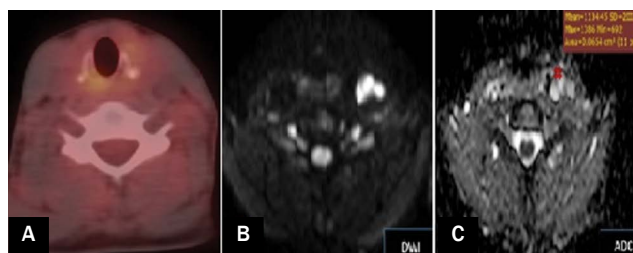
31-year-old woman presented with PTC, underwent total thyroidectomy. Follow up assessment (3 months post-thyroidectomy): revealed rising TG level reached 7.1 ng/mL. PET/CT showed no FDG avid lesions (A). Conventional MRI showed left cervical level IV lymph node with suspicious features with bright signal on diffusion mostly T2 shine through effect (B), high ADC value = $1.1 \times 10^{-3} \text{ mm}^2/\text{s}$ (C). Pathological assessment revealed: metastatic papillary carcinoma
